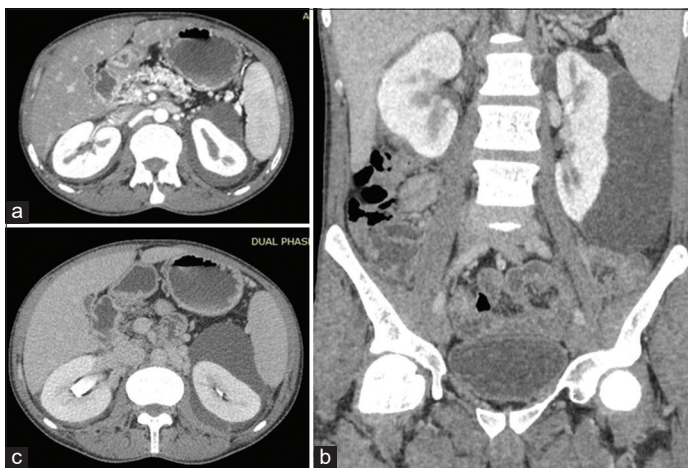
(a) Bilateral perirenal collections with Computed Tomographic value of 0–10 Hounsfield’s Unit-corticomedullary phase in axial reformat; (b) nephrographic phase-septum is seen at upper pole on left side with bilateral perirenal collections in coronal section; (c) Excretory phase-bilateral kidneys showing normal excretion in axial image
